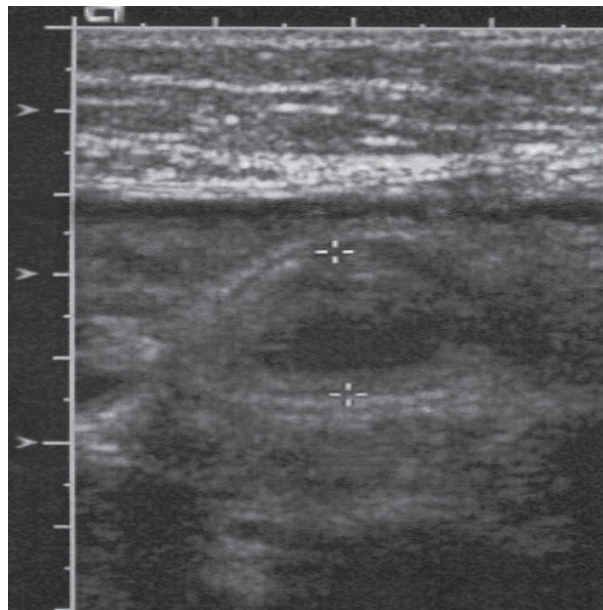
Ultrasound Finding of Appendix
